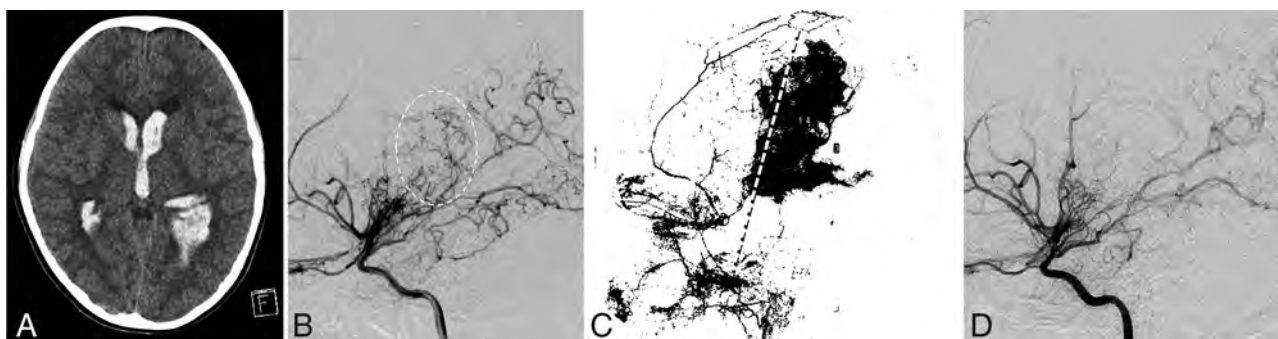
Case 1 (a 9-year-old girl). A, CT at onset shows intraventricular hemorrhage. B, Preoperative left internal carotid angiography shows choroidal anastomosis (dotted circle), which corresponds to the hemorrhage site. C, Quantitative measurement of the revascularization area in the left hemisphere. The revascularization areas anterior and posterior to the CS are 3.4% and 16.1%, respectively. The dotted line indicates the CS. D, Postoperative left internal carotid angiography shows reduction of choroidal anastomosis.
